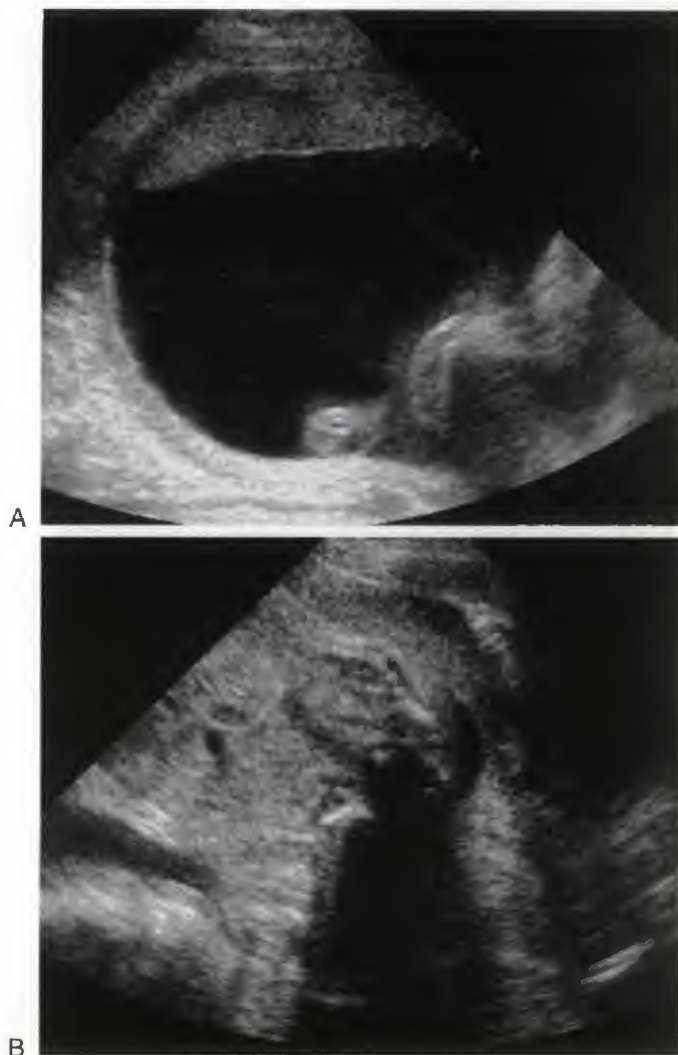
Sonogram in a moderately obese patient. Artifactual echoes within the amniotic fluid make the actual amniotic fluid less apparent.
